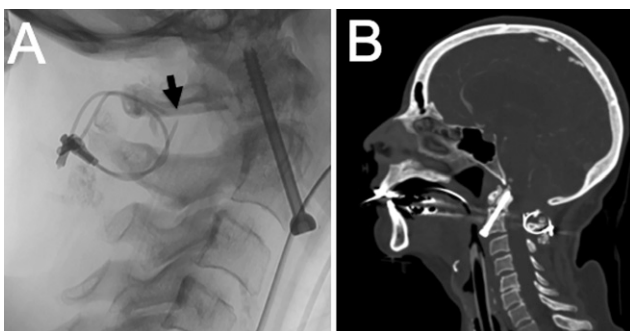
A: Lateral radiograph of the upper cervical spine with the arrow highlighting the fractured sublamina wire. B: Sagittal contrast CT angiography showing fractured sublamina wire and the absence of other vascular lesions.
